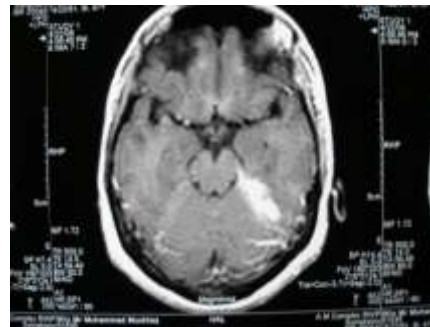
MRI confirms thickening of dura of tentorium.
